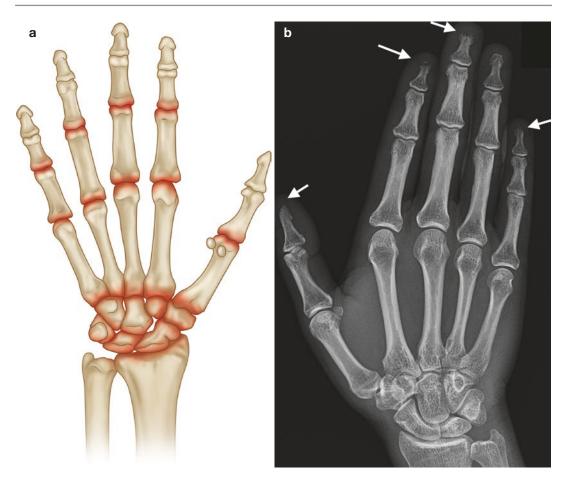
(a) Common sites of involvement with connective tissue disease. (b) PA radiograph of the right hand with scleroderma demonstrating resorption at phalangeal tufts (*arrows*), acro-osteolysis. No significant overlying
